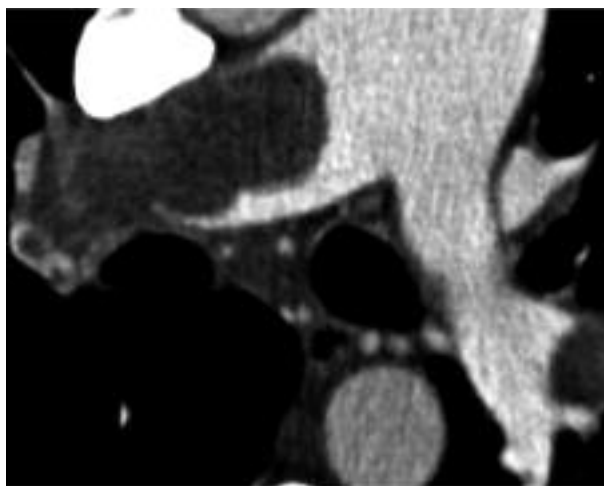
CT angiography was immediately performed, showing evidence of massive TEP, increased pulmonary artery trunk diameter (47 mm)
